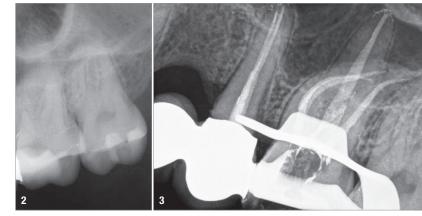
Initial radiograph. Fig. 3: Post-op radiograph.
